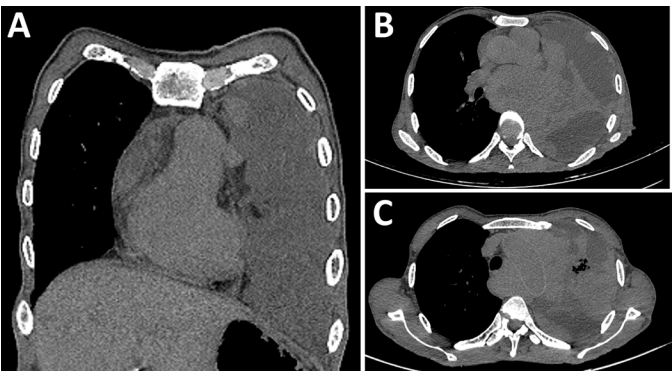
Non-contrast CT images of the chest demonstrating the primary thoracic disease. (A) Coronal image showing a soft-tissue mass in the left lung upper lobe with associated collapse-consolidation of the adjacent lung. (B, C) Axial images showing the left lung upper lobe mass with associated pleural effusion, consistent with advanced primary lung malignancy.
